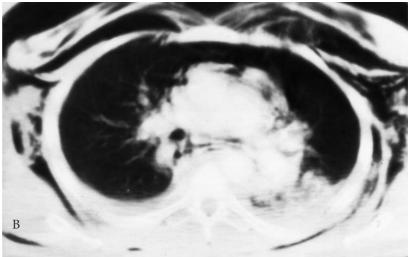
Acute left main bronchial rupture. Computed tomography scans through the carina (A) and left main bronchus (B) reveal extensive pneumomediastinum, subcutaneous emphysema, and a leftsided pneumothorax. There is marked narrowing of the left main bronchus at the site of laceration (B).
